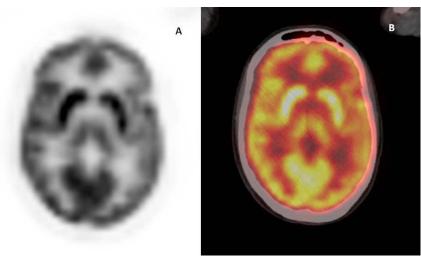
18-FDG PET scan for treatment evaluation (PET alone on the left and PET/CT fusion image centered on the brain in axial section on the right). Cortical uptake of the glucose analogue begins to decline.
